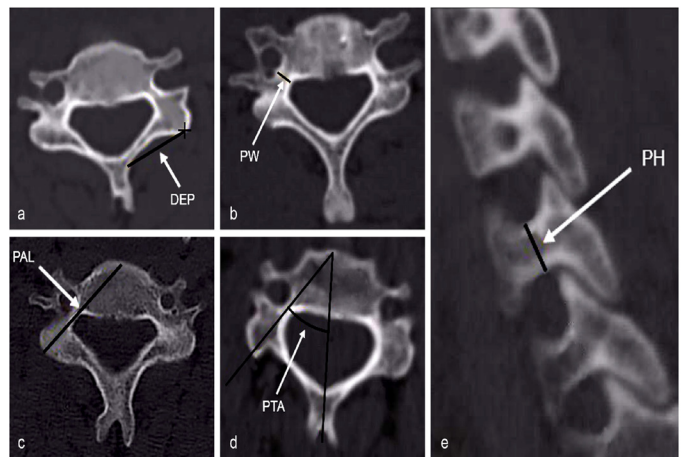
Parameters measured on computed tomography. Distance from the junction of the lamina and spinous process to the entry point (DEP) (a). Pedicle width (PW) (b). Pedicle axis length (PAL) (c). Pedicle transverse angle (PTA) (d). Pedicle height (PH) (e)
